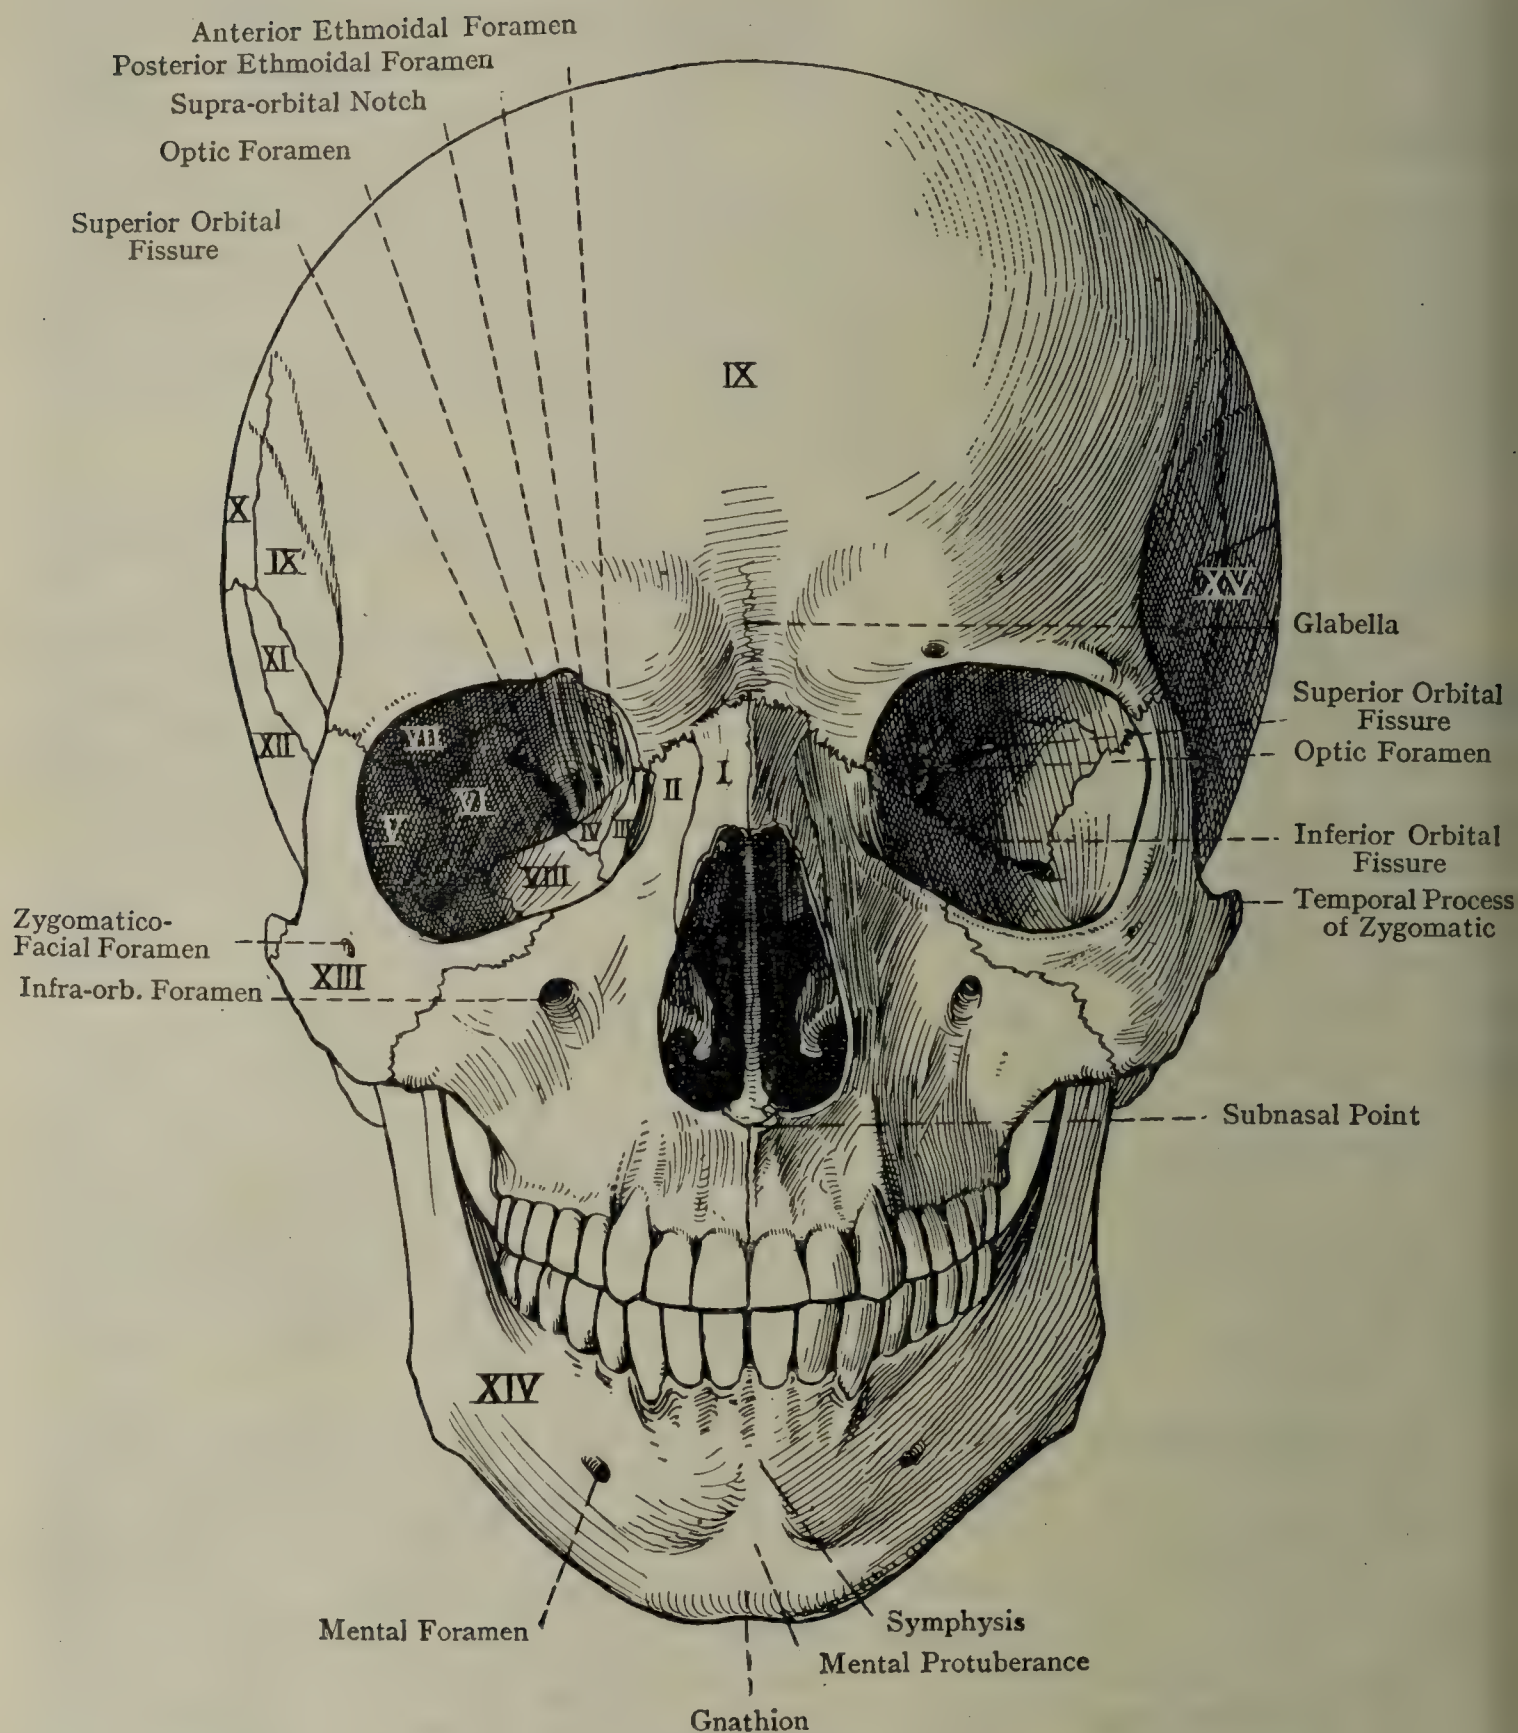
THE ANTERIOR ASPECT OF THE SKULL (NORMA FRONTALIS ET FACIALIS).
